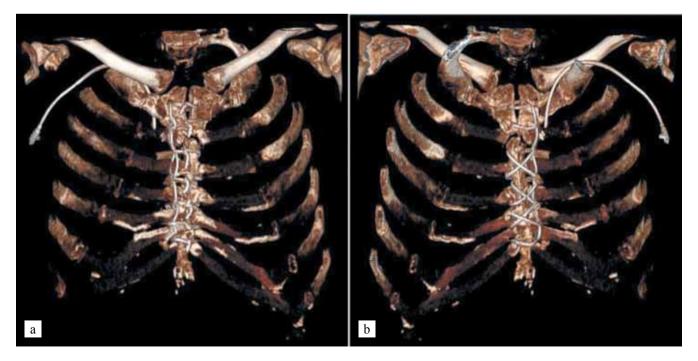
Sternal reosteosynthesis by Robicsek technique: a) along the front and b) along the inner surfaces of the sternum. 3D reconstruction of CT scan
